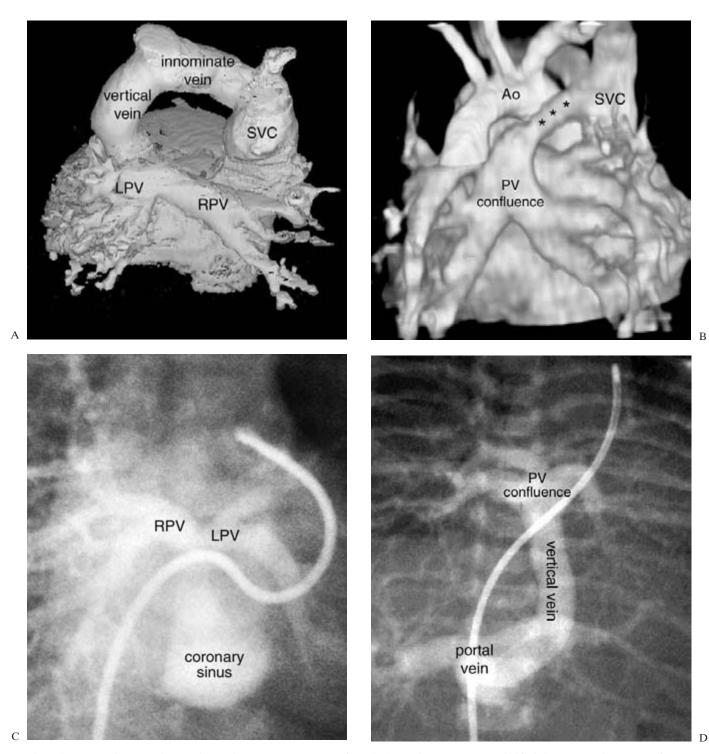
2 Examples of total anomalous pulmonary venous connections. A. CT angiogram seen from behind shows anomalous connection to the innominate vein. (Courtesy of Dr Yang Min Kim, The Sejong Heart Institute, Korea.) B. MR angiogram seen from behind shows anomalous connection to the superior vena cava (SVC). The vertical vein connecting the pulmonary venous (PV) confluence shows long segment narrowing (asterisks). C. X-ray angiogram shows anomalous connection to the coronary sinus (CS). D. X-ray angiogram shows anomalous connection to the portal vein. Ao, aorta; LPV, left pulmonary vein; PV, pulmonary vein; RPV, right pulmonary vein.
